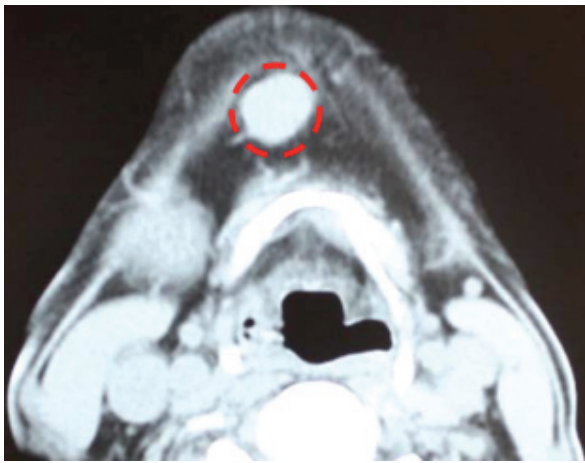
A computed tomography scan of the neck. The red circle indicates submental lymph node metastasis.
